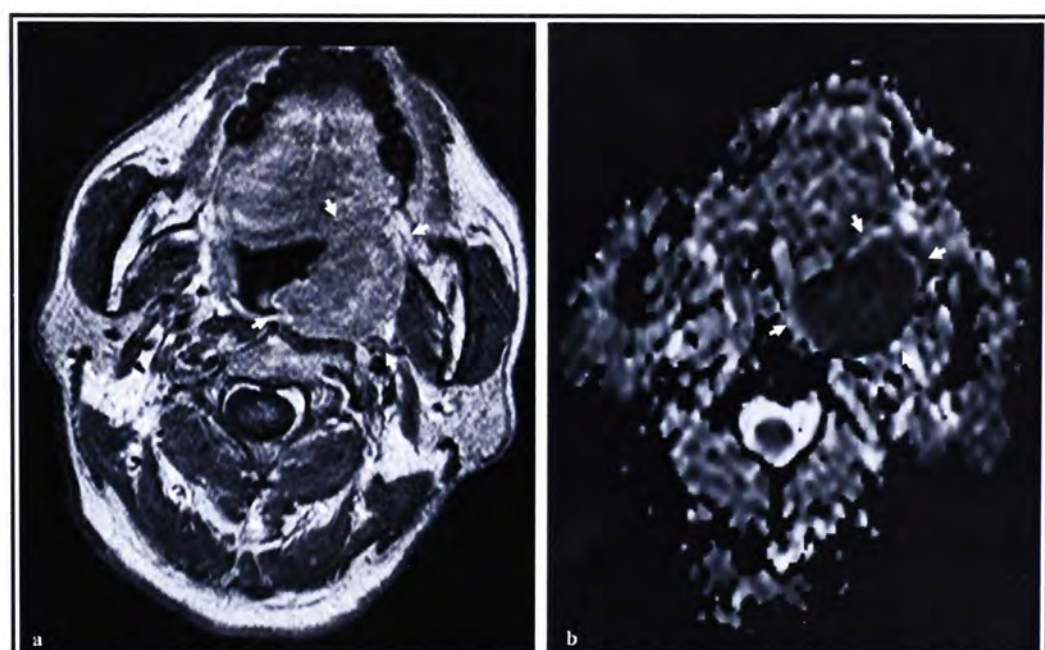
Extra-nodal NHL in a 65-year-old man. The axial post-contrast T1W MR image (left) and ADC map (right) show the primary tumor (arrows) with ADC value of $0.736 \pm 0.201 \times 10^{-3} \text{ mm}^2/\text{s}$.
